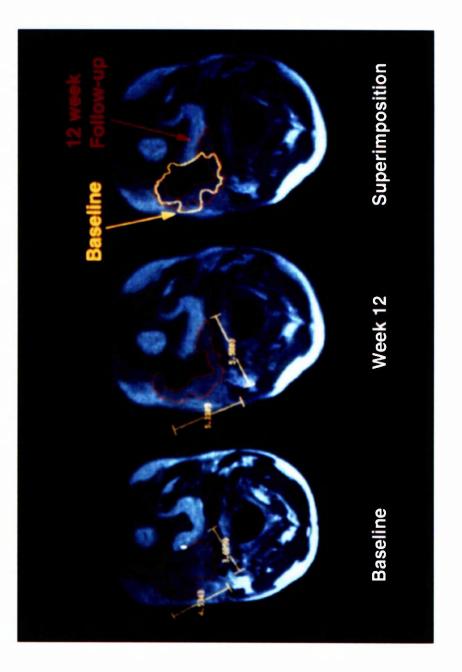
Patient 1003 had a primary tongue tumour and developed local recurrence in the right submandibular region. The depth of the tumour is shown in the baseline MRI scan outlined in red. 50% necrosis of the tumour occurred after 3 cycles of treatment. The area of necrosis and is shown on the week 12 MRI scan.
